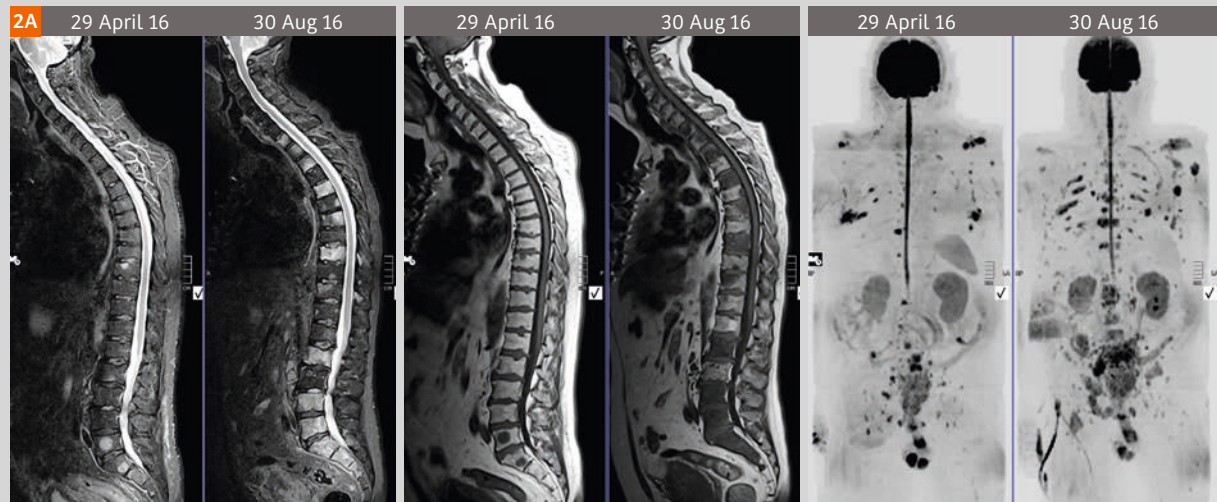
Marked disease progression can be seen on morphology T1-weighted and STIR sequences and on WB b900 MIP images and confirmed by ADC measurements (see Fig. 2D also). Disease progression is seen in the prostate gland with extensive bladder invasion together with rectal invasion. There is disease progression in pelvic and retroperitoneal lymph nodes with nodal enlargement in the left axilla also. There is bone disease progression throughout the spine with extra-osseous soft tissue disease with new and enlarging deposits. No liver or lung disease is seen. The spinal stenosis at L3/L4 is degenerative in nature.
